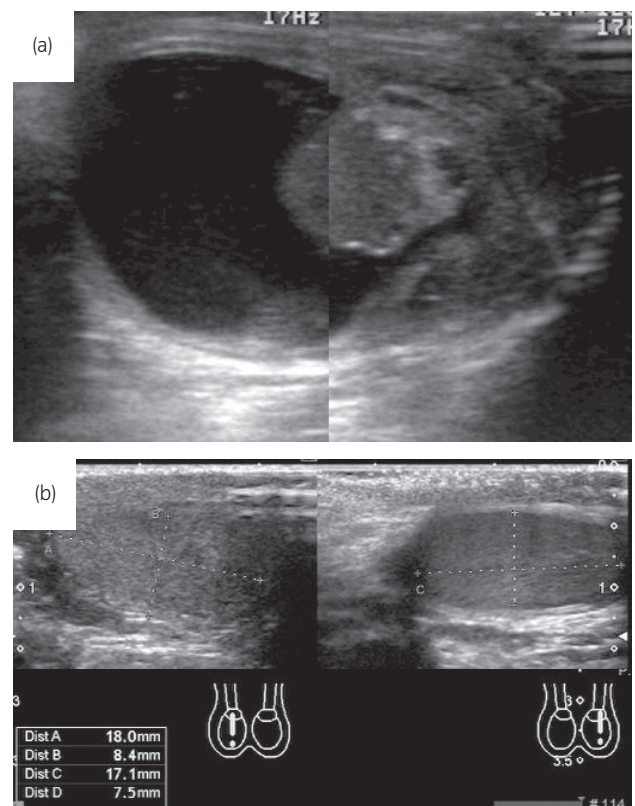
Ultrasound image in Case 4. (a) Preoperative image showed tumor arising inside a cyst that displacing normal testicular tissue to periphery. (b) Postoperative follow-up image showed that affected right testis retained equivalent volume to contralateral testis.
